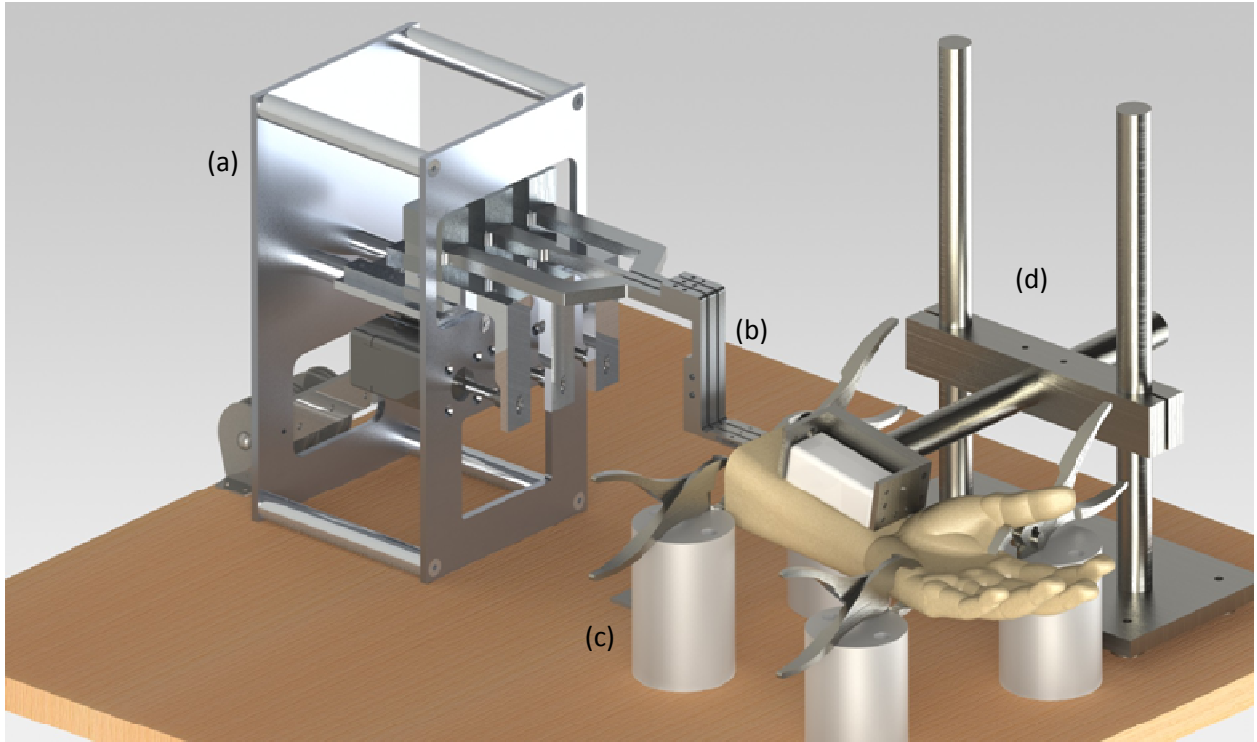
The hardware for Experiment 4 is comprised of: (a) a multi-tendon actuation system, (b) tendon couplers, (c) a cadaver stabilization system, and (d) the quad-array transducer and holder. Other components not shown in here includes a computer, a custom acrylic box containing the Galil controller and drivers, and the Ultrasonix Touch ultrasound machine.
